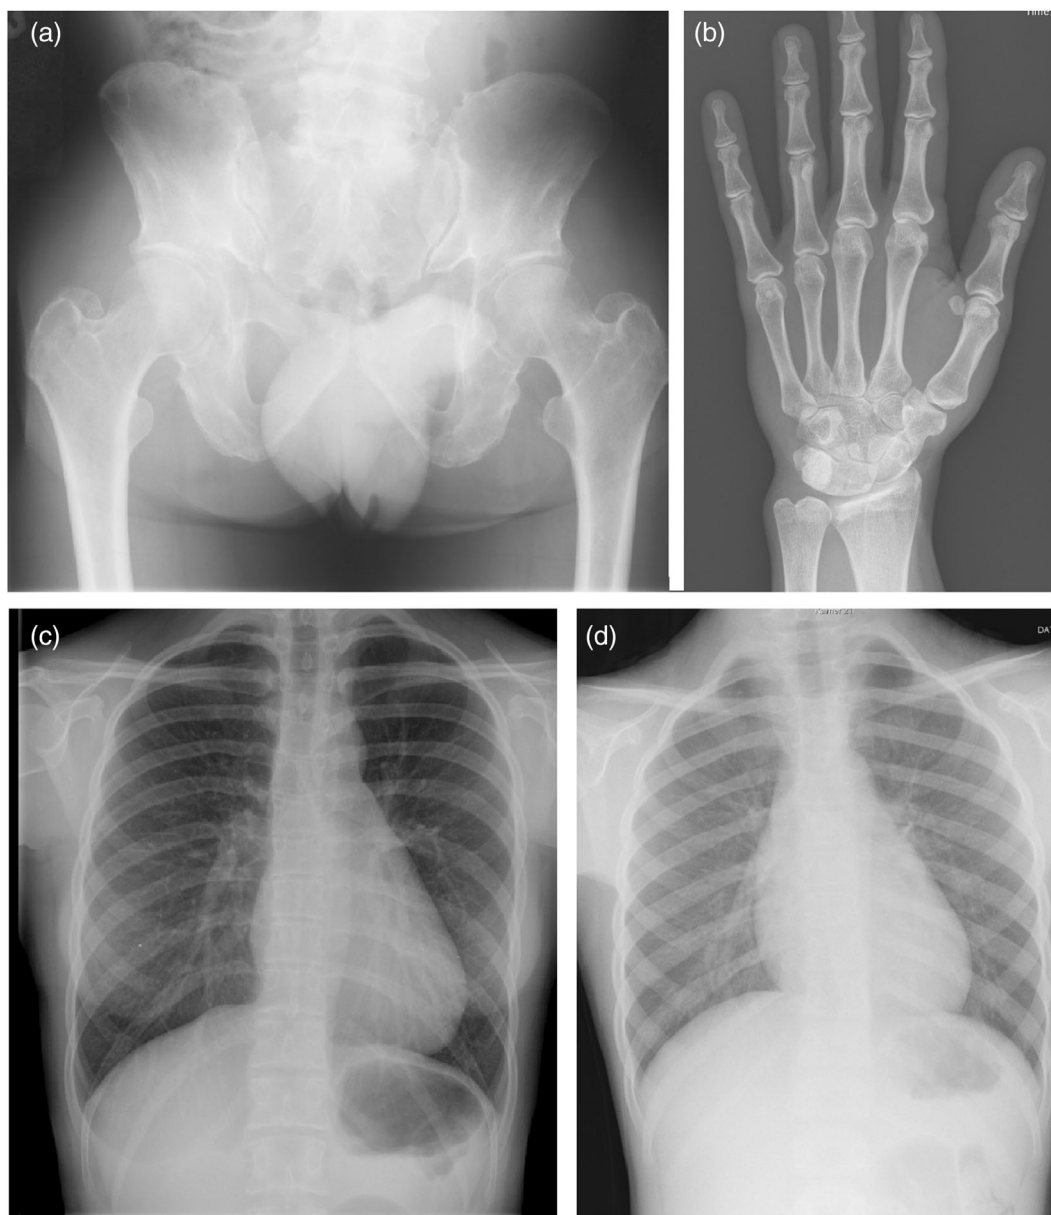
X-ray of the pelvis, hand, and thorax. X-rays of the (a) pelvis (II-1), showing hypoplasia of the iliac wings; (b) hand (II-1), showing fusion of the carpal bones and thorax (II-1 [c], and III-1 at 8 years of age [d]) showing hypoplasia of the scapulae.
